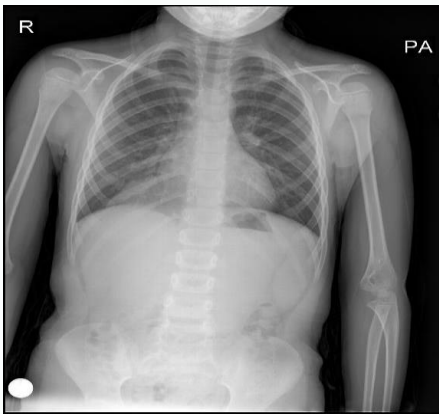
PA Chest x-ray of the patient
